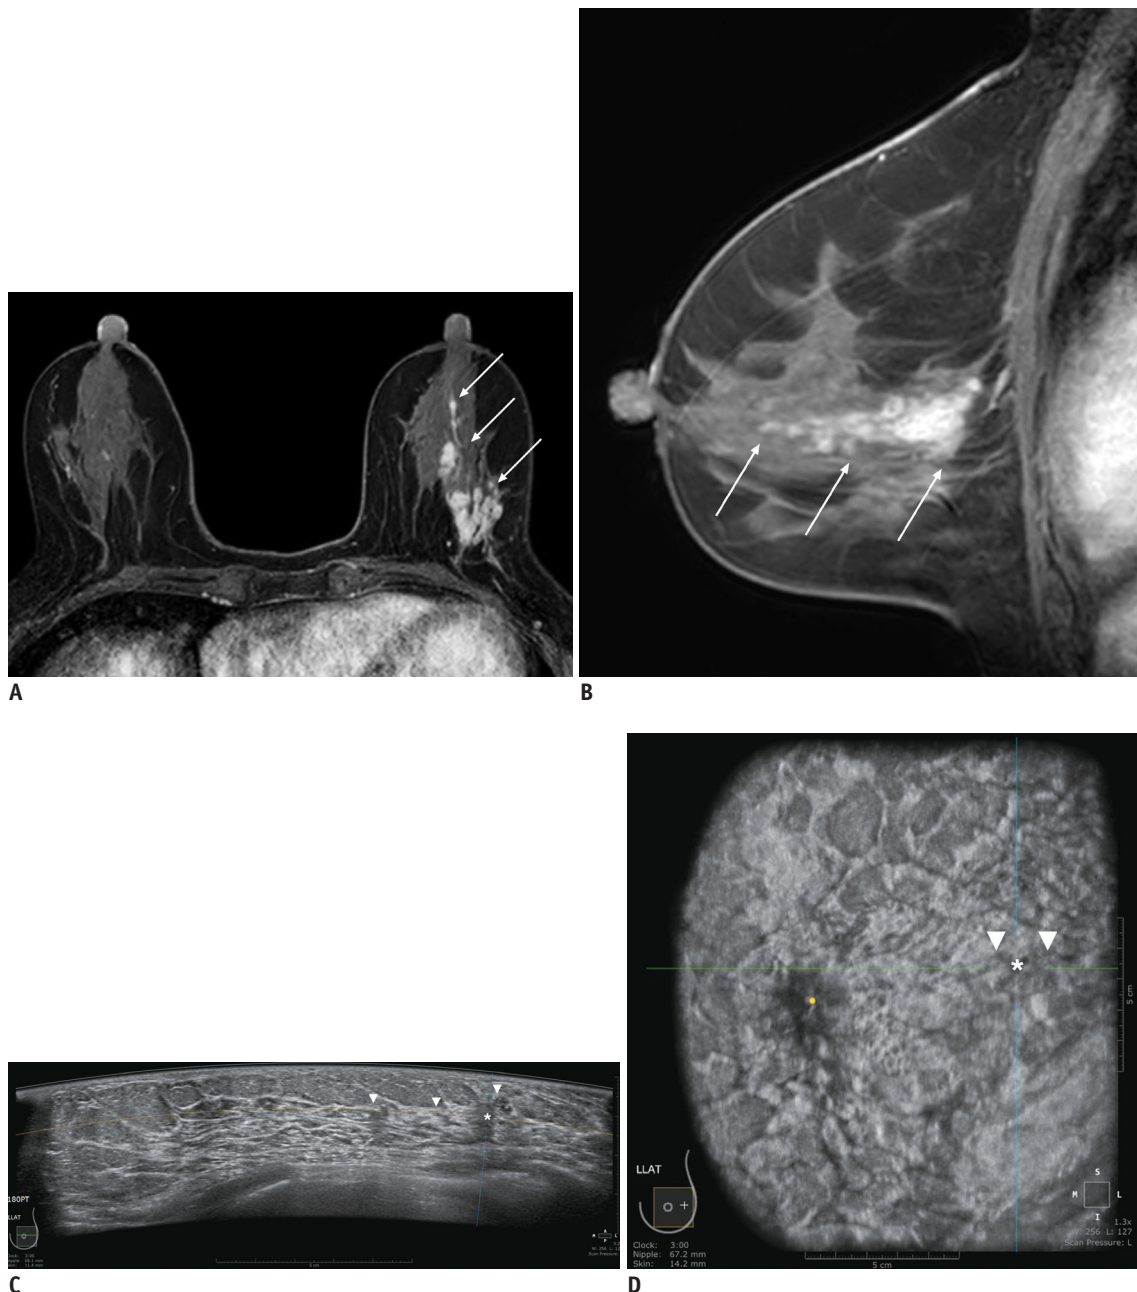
59-year-old female with left breast cancer who underwent MRI and ABUS for preoperative staging. Axial (A) and sagittal (B) dynamic contrast-enhanced MRI show segmental, heterogeneous non-mass enhancements (arrows) at left upper outer breast. ABUS images show ill-defined hypoechoic mass (asterisk) with ductal changes (arrowheads) on axial (C) and coronal (D) planes of left breast. Lesion measured 2.8 cm on ABUS and 5.8 cm on MRI. Mass was classified as BI-RADS category 4B. This patient subsequently underwent left modified radical mastectomy, and finally confirmed to have microinvasive carcinoma in background of DCIS. ABUS = automated breast ultrasound system, BI-RADS = Breast Imaging Reporting and Data System, DCIS = ductal carcinoma *in situ*
